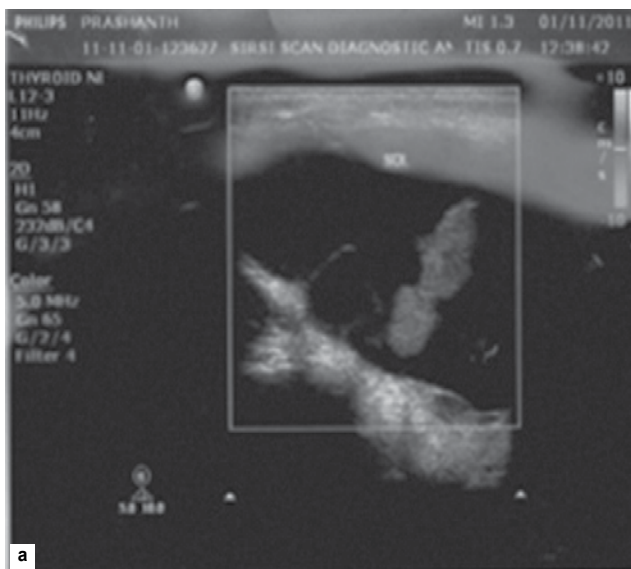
a and b. A well-defined, rounded, predominantly cystic lesion of size 4.3 × 2.7 cm on ultrasound.
